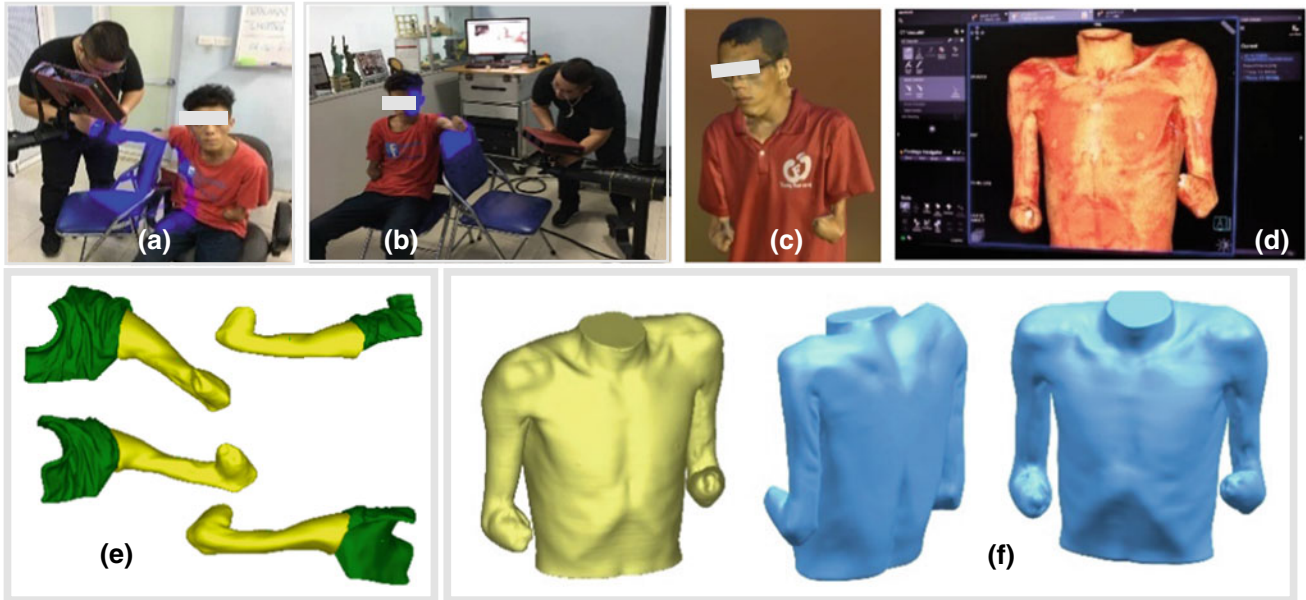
Data collection and 3D modeling of the body parts for design activities. a, b RE scanning. c, e 3D models constructed from scanned point data. d, f 3D models constructed from CT images
